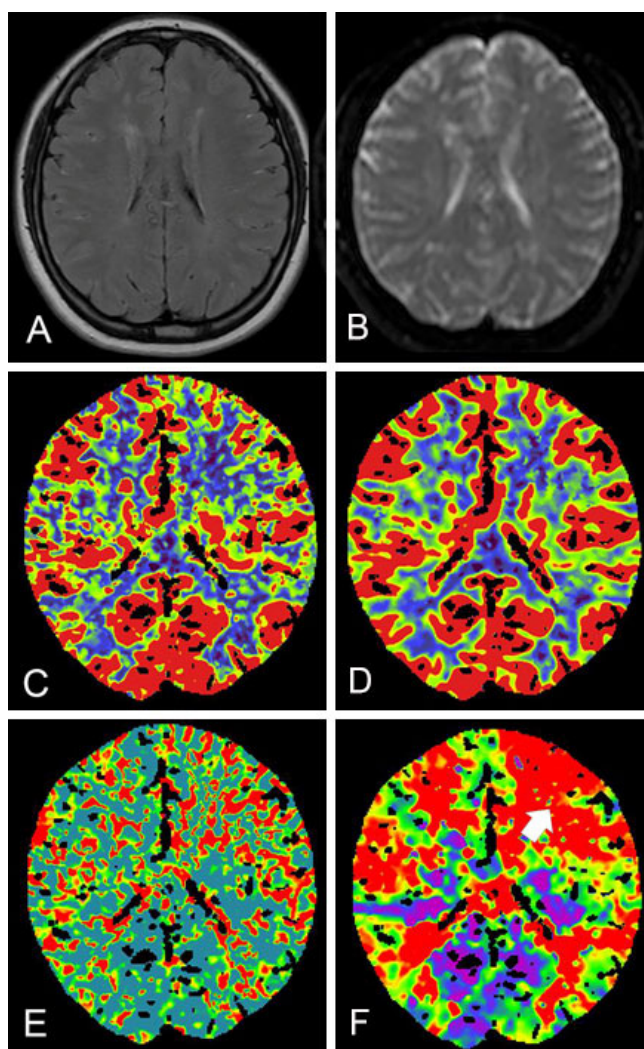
Preoperative magnetic resonance image and perfusion CT. No acute cerebral ischemic lesion on preoperative FLAIR (A), DWI (B), perfusion CT revealed mild reduced CBF (C), and CBV (D) along with increased MTT (E) and TTP (F) at left frontal lobe (white arrow). CT: computed tomography; CBF: cerebral blood flow; CBV: cerebral blood volume; DWI: diffusion weighted image; FLAIR: fluid attenuated inversion recovery; MTT: mean transit time; TTP: time to peak
